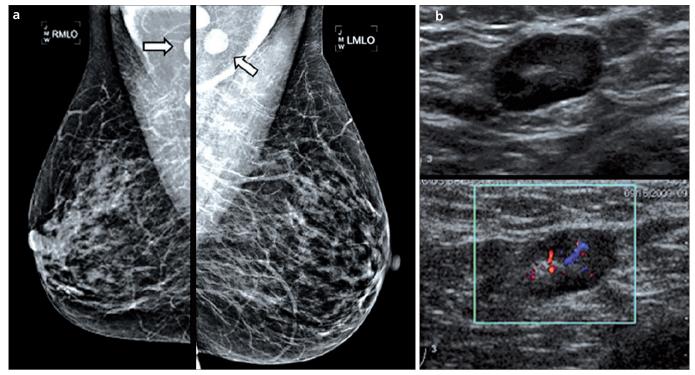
a, b. MLO views (a) of bilateral breasts show multiple round, dense, enlarged lymph nodes in a patient with history of stomach cancer who presented with bilateral lumps in the axillary regions (*arrows*). A round hypoechoic lymph node with a diffusely enlarged cortex is seen on US, and color Doppler US shows increased central flow (b).
